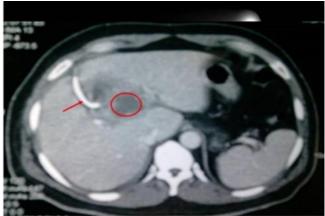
CT scan of abdomen showed liver abscess with drainage tube inside the abscess.
